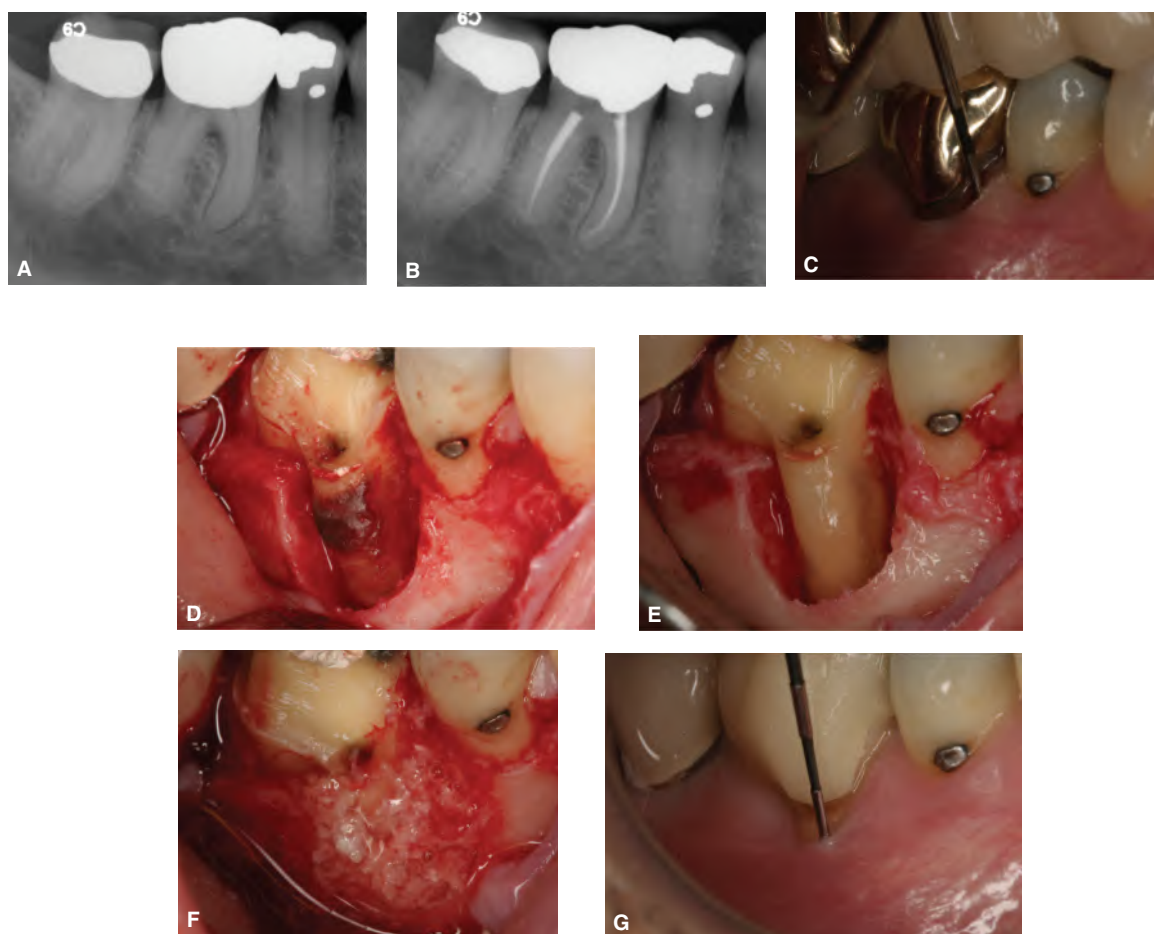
Primary endodontic disease with secondary periodontal involvement. A. Pre-operative radiograph of a symptomatic lower right first molar. Pulp sensibility tests were negative. Initial diagnosis of periapical periodontitis caused by a necrotic pulp was established. B. Endodontic treatment was done, however, residual deep pocket (7-9 mm) on the mesial root remained. C. Examination reveals a large mucogingival defect with minimal keratinization and absence of attached gingiva. D. Upon exploration, severe bone loss and abundant calculus on the mesial root were observed. E. The root surface was then debrided and the bony defect cleaned. F. Bony defect is repaired with bone graft material and a resorbable membrane. G. Two-month follow-up shows active healing of the defect. (Courtesy of Dr. Ziv Simon, Beverly Hills, CA, U.S.A.)
